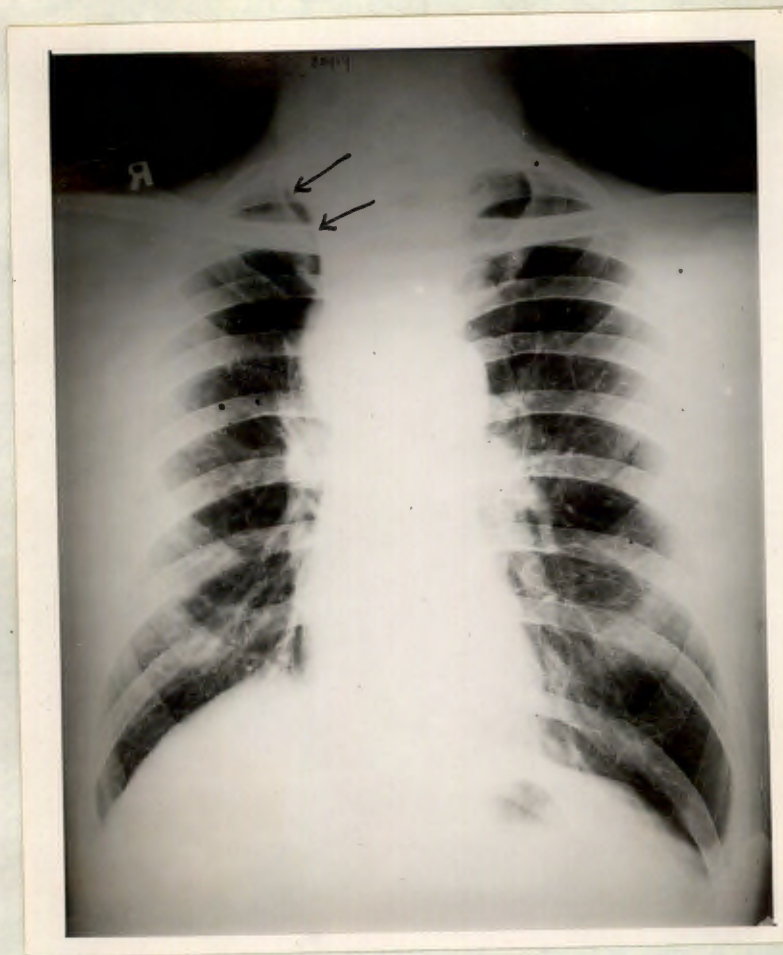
Postero-anterior radiograph showing an atelectatic right upper lobe lying very close to the vertebral shadow. This was a proved case of bronchial carcinoma.
